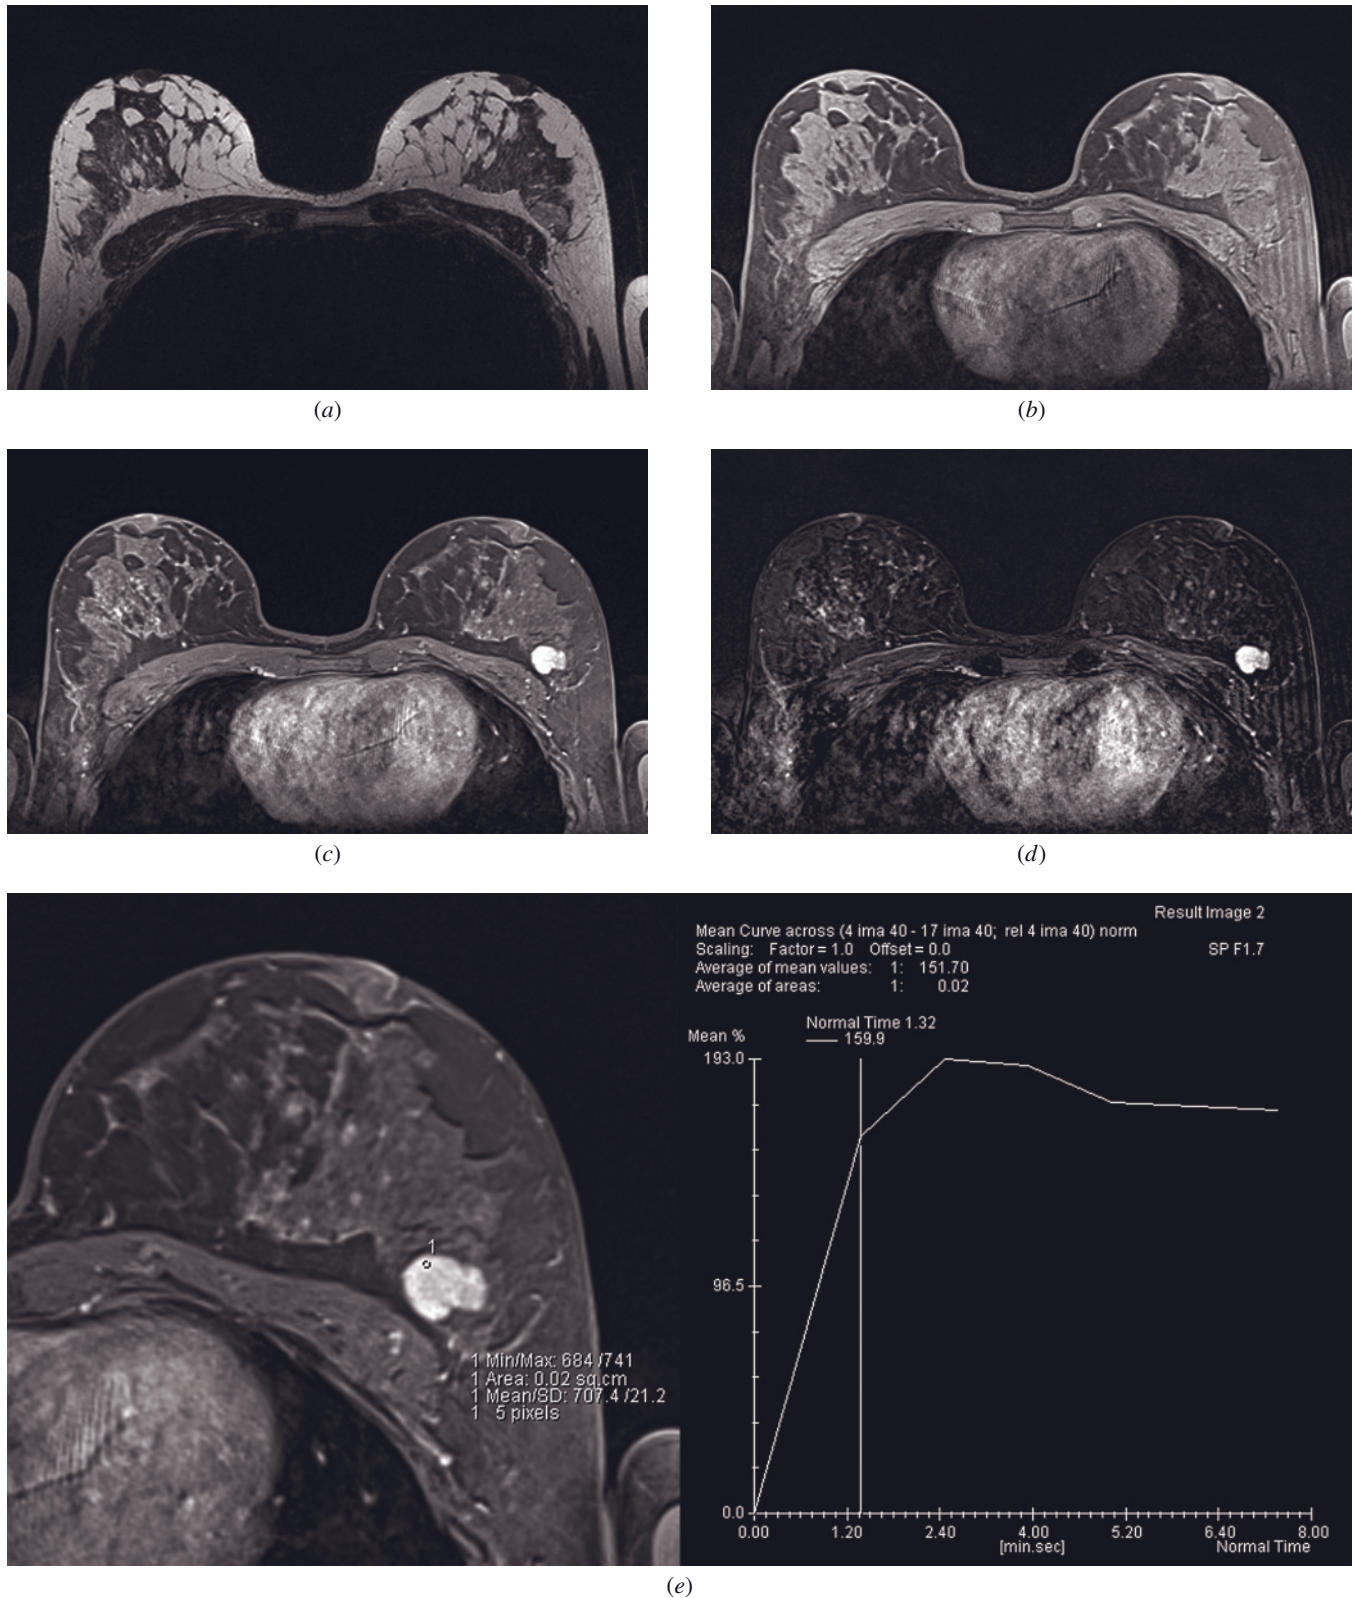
Fibroadenoma (FA). Axial T2-weighted image (a) of a typical fibroadenoma reveals isointense lesion with irregular hypointense central sections due to the fibrous components of the FA. On axial precontrast GRE image (b), the lesion appears isointense to the surrounding parenchyma. Axial postcontrast GRE (c) and subtracted (d) images show enhancing lesion with slightly inhomogeneous central part. ROI analysis with time-intensity curves (e) shows a typical plateau curve (Type II) reaching a maximum enhancement (193%) 2.5 min after GBCA administration. This curve with typical morphology of FA does not influence BI-RADS categorization, and the lesion is categorized as BI-RADS 2. The mass remained mammographically stable after the 2-year follow-up.
